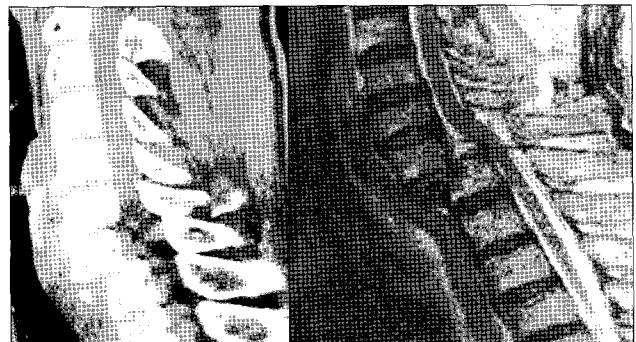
Computed tomography scan of the cervical spine with sagittal three-dimensional reconstruction and sagittal T2-weighted magnetic resonance image scan demonstrates a large disc compressing the lower cervical cord. There is also a fracture of C7 with an anterior dislocation.
